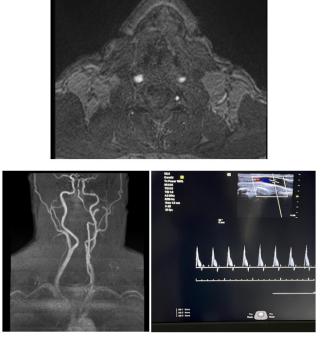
Case 2- MR angio neck vessels revealing hypoplastic right vertebral artery. However, USG doppler appears normal
